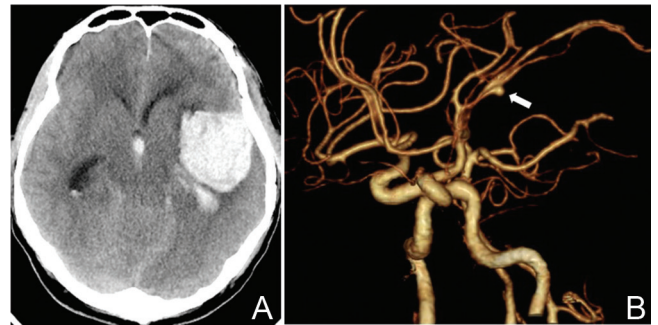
A: Computed tomography (CT) scan obtained 6 months after the initial operation revealing hemorrhage in the tumor cavity and subarachnoid hemorrhage. B: CT angiogram showing an aneurysm (arrow) at the M2 portion of the left middle cerebral artery.
